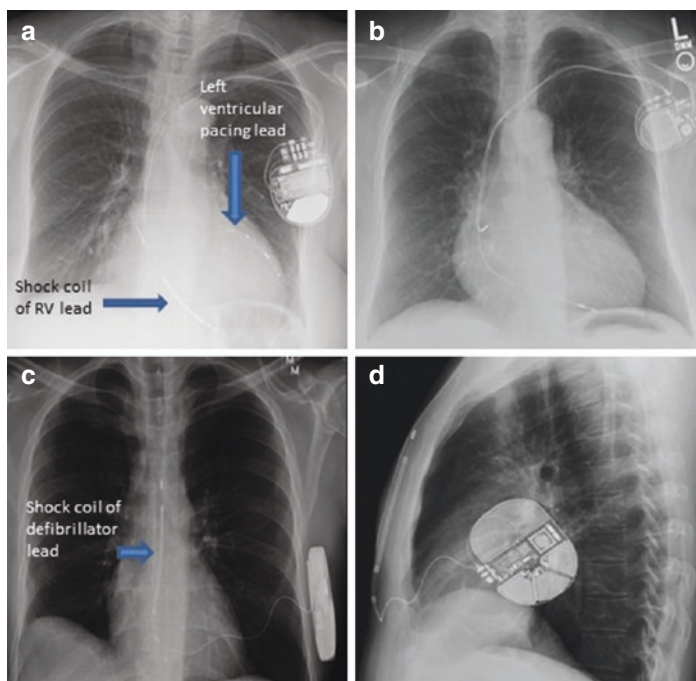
Postero-anterior chest X-ray appearance of a CRT-D (a) a dual chamber pacemaker (b) and postero-anterior and lateral image of a S-ICD (c, d) showing the subcutaneous location of the pulse generator and the defibrillator lead
